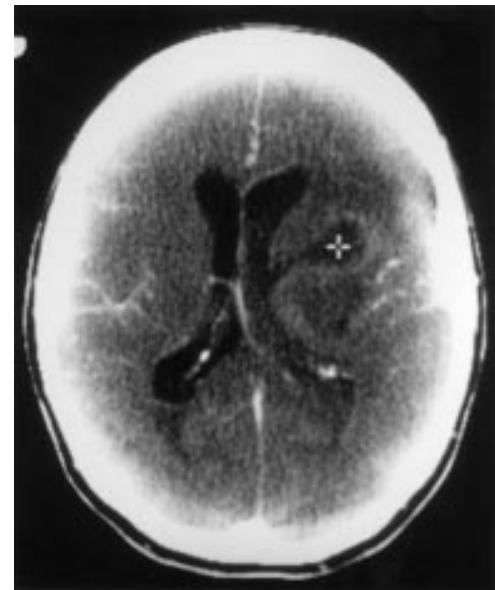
Computed tomography of the brain following the sudden deterioration.
